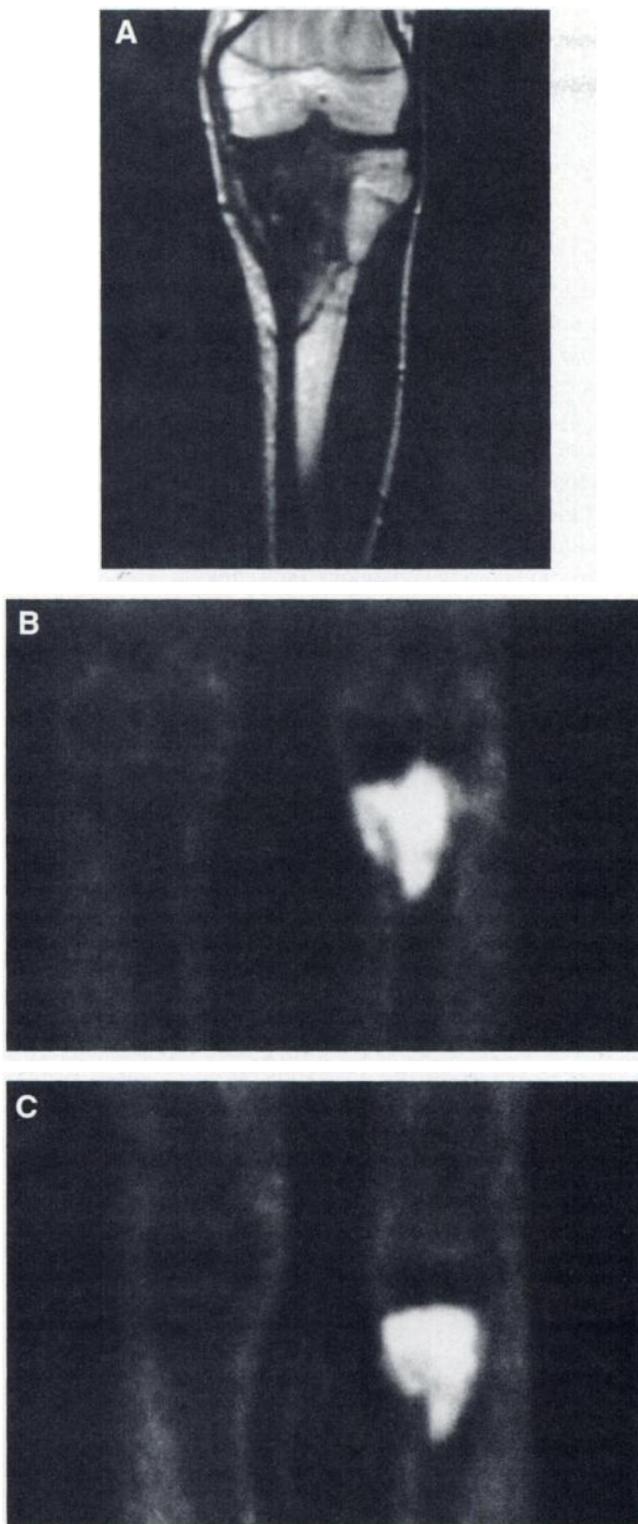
Eighteen-year-old man with osteoblastic osteosarcoma stage IIB of left proximal tibia (patient 4). (A) T1-weighted unenhanced coronal spinecho MR image shows extension of lesion. (B) Coronal FDG PET scan before incision biopsy shows highly elevated glucose metabolism of tibial head. (C) Coronal FDG PET scan after neoadjuvant chemotherapy. Hypermetabolic area appears unchanged. With viable tumor fraction of 22%, patient had to be classified as nonresponder grade IV.
